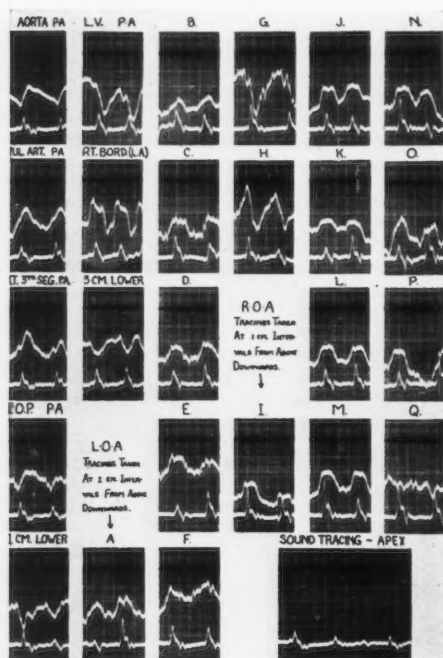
The electrokymograms of the various borders of the cardiovascular silhouette of a 36 year old white woman with compensated rheumatic heart disease, mitral stenosis and insufficiency, and auricular fibrillation. The phonocardiogram, obtained from the left fourth intercostal space parasternally, and the carotid sphygmogram were simultaneously recorded. P.O.P. refers to the point of opposite pulsations, L.V. the left ventricle, and L.A. the left atrium.
